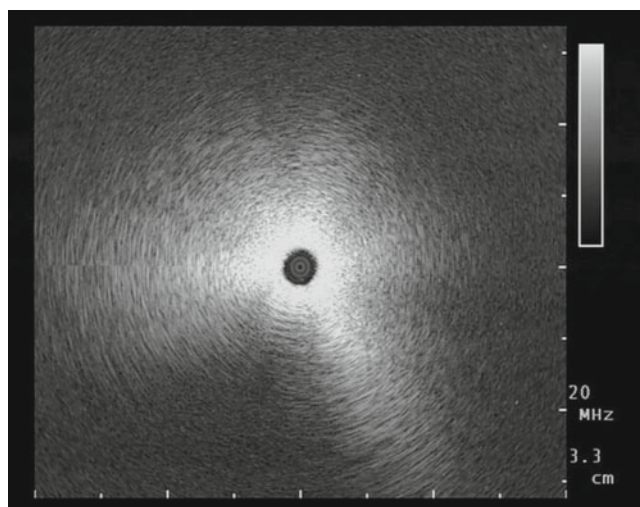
A “snowstorm-like” ultrasound image, characteristic of normal ventilated, peripheral lung
